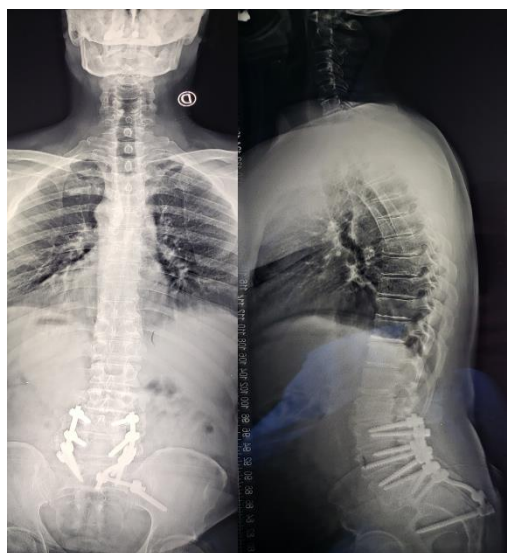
A-B Preoperative (EOS) X-ray showing sagittal imbalance and previous posterior surgery performed L2-S1
